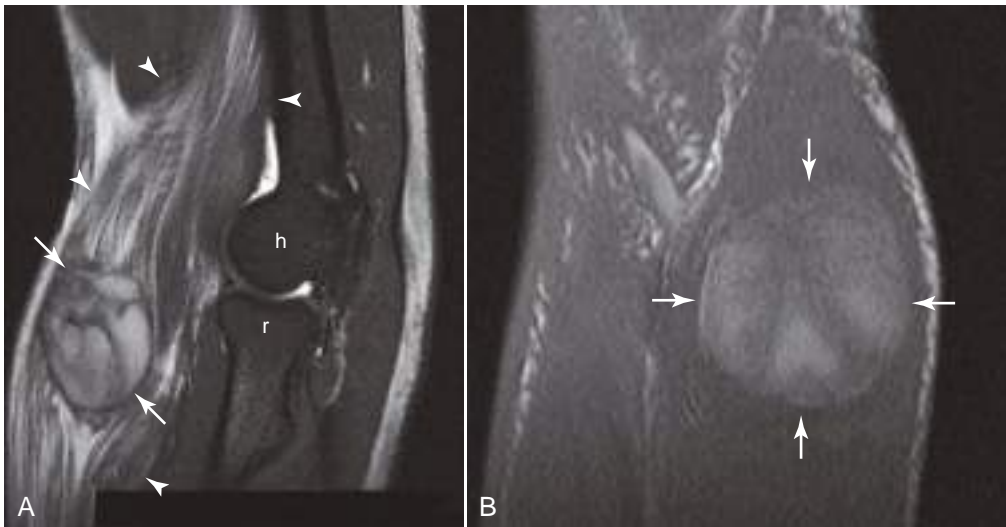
Muscle laceration and hematoma. MR images in a patient with brachialis muscle injury. Sagittal fat-suppressed T2-weighted MR image (A) shows bright edema signal interposed between brachialis muscle fibers (arrowheads). A masslike hematoma (arrows) with complex signal is located between interrupted muscle fibers. Coronal T1-weighted image (B) shows elevated signal of methemoglobin in the hematoma (arrows). *h*, Distal humerus; *r*, proximal radius.
